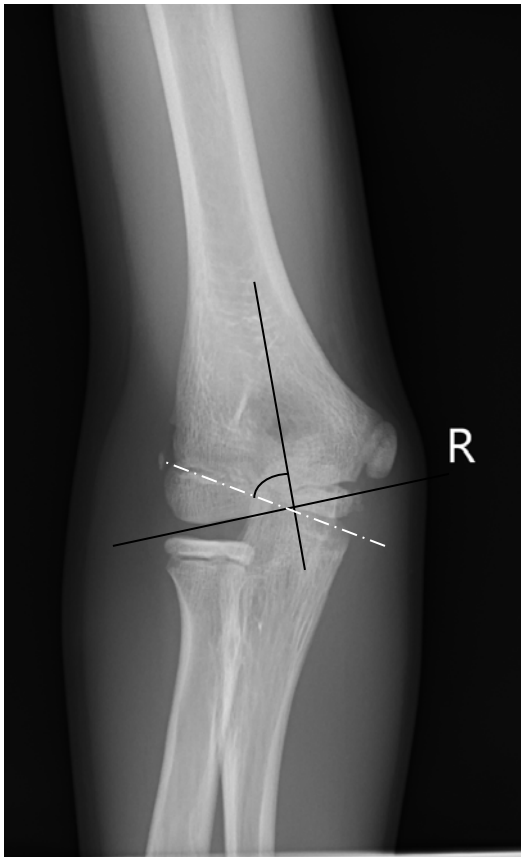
AP radiograph of the elbow with the normal Bauman angle
